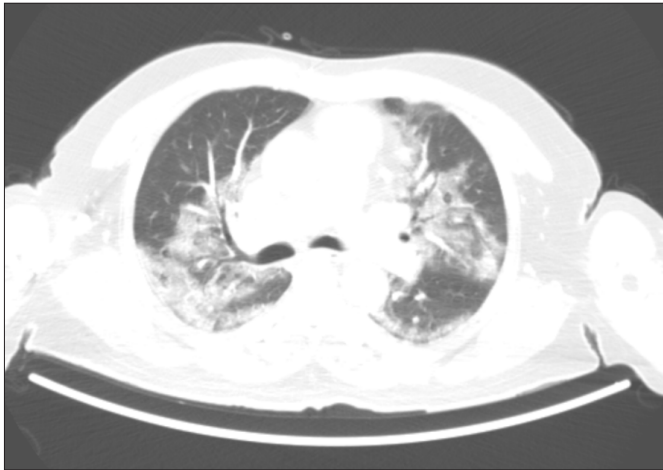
Chest CT scan showing pulmonary lesions typical of COVID-19.
